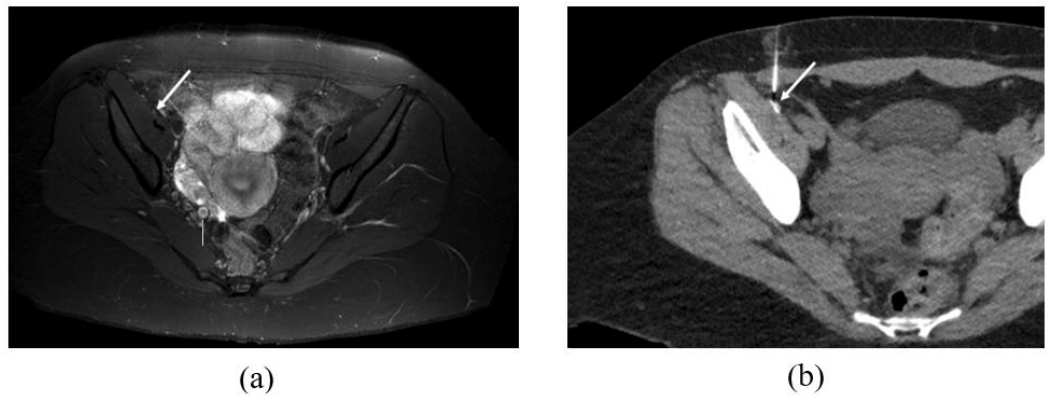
CT Acquisitions During Pulsed Radiofrequency Ablation of the Genitofemoral Nerve. (a) Axial T2 DIXON water-only 3T-MRN image shows a slightly thickened right genitofemoral nerve proximal to the inguinal canal (white arrow); (b) Axial CT demonstrates accurate needle placement along the genitofemoral nerve path, confirmed by its location adjacent to the psoas major muscle (white arrow).
